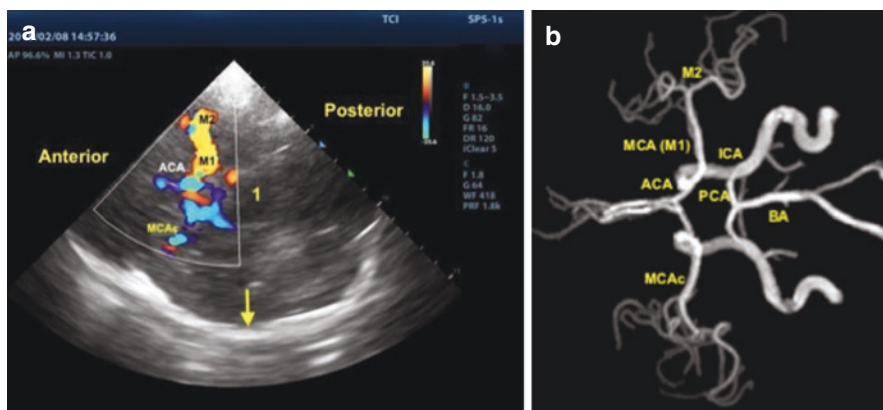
(a) Circle of Willis by TCCS through transtemporal acoustic window: (1) mesencephalon, (M1) ipsilateral M1 segment of middle cerebral artery (red), (M2) M2 segment of middle cerebral artery, (ACA) anterior cerebral artery, (MCAc) contralateral middle cerebral artery (blue), (arrow) contralateral skull. (b) Angio-MRI of circle of Willis: MCA (M1): M1 segment of middle cerebral artery, (M2) M2 segment of MCA, (ICA) internal carotid artery, (PCA) posterior cerebral artery, (BA) Basilar artery, (ACA) anterior cerebral artery, and (MCAc) contralateral middle cerebral artery. (Author: Camilo N Rodríguez)
